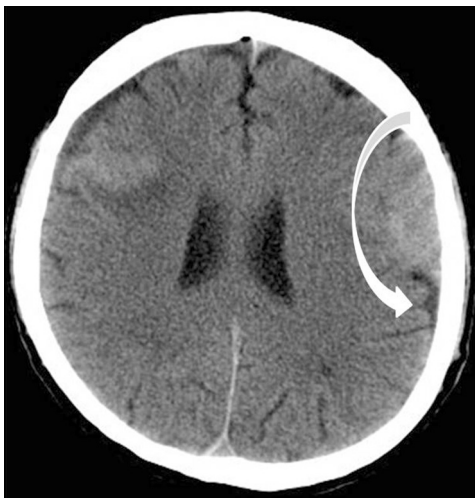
Left sided hyperdens lentiform image on computed tomography
